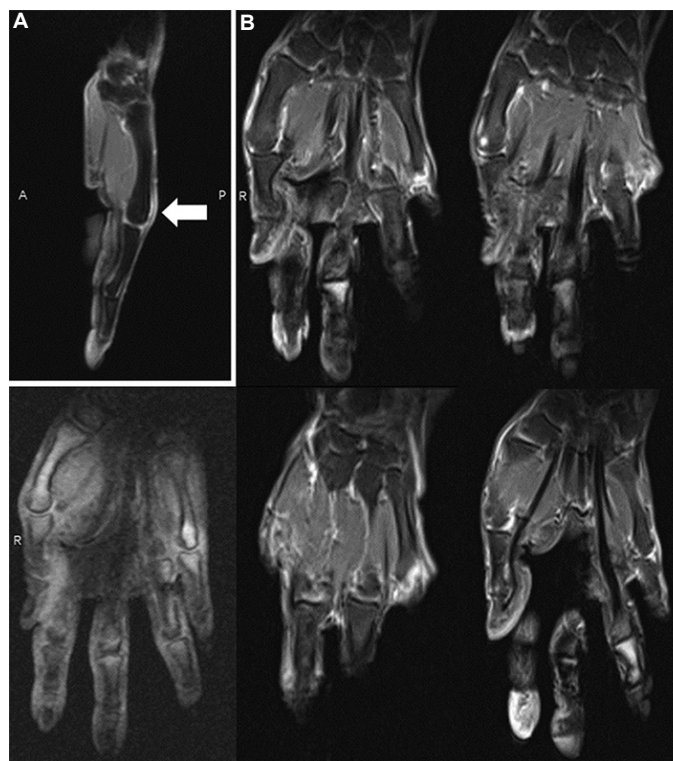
(A) Sagittal magnetic resonance imaging of hands showing enthesitis (arrow), and (B) coronal magnetic resonance imaging revealing no bone marrow oedema nor cortical damage.
